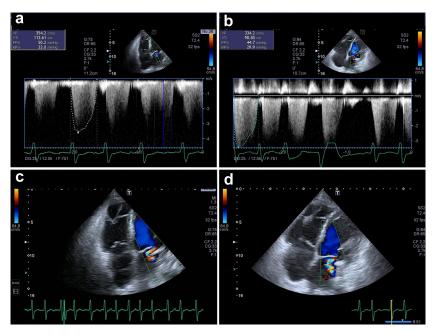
Mitral regurgitation by (a, c) tele-echocardiography and (b, d) reference echocardiography.
